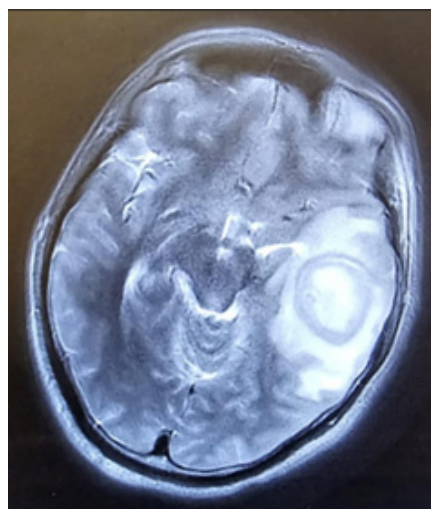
Axial T2-weighted magnetic resonance imaging demonstrating a well-defined lesion in the left temporal lobe with a hyperintense central cavity surrounded by a hypointense capsule, consistent with a brain abscess. Extensive perilesional vasogenic edema is observed in the adjacent temporal lobe parenchyma, producing local mass effect.
